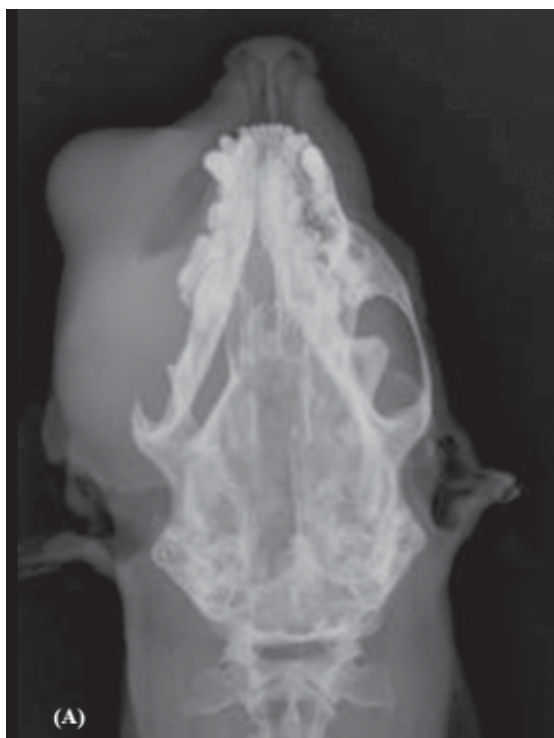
Radiographic examination of the skull dorsoventral view showing a large soft tissue opacity mass at left side of head affected to loss of left zygomatic arch (A). Right lateral view showing a soft tissue opacity mass at the rostro dorsal area with a bone lysis at rostral part of mandibular (B).
